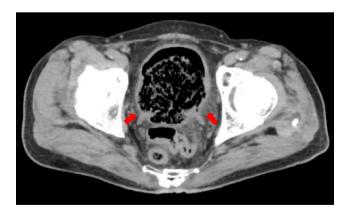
CT revealing excessive spherical masses with gas in the bladder (arrows)
